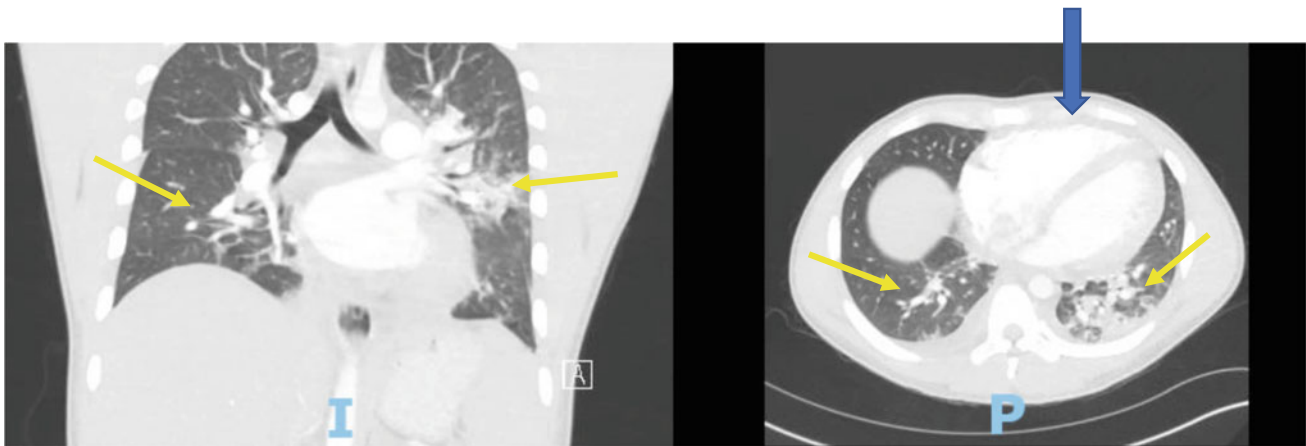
CT angiography of the chest showing patchy opacities in bilateral lobes (yellow arrows) and new cardiomegaly (blue arrow)
